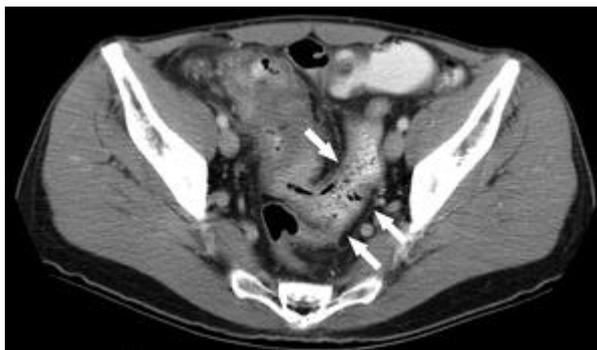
Small-bowel obstruction secondary to adhesions. CT scan obtained shows transition point (arrows) with dilated bowel proximally and collapsed bowel distally. No pathologic process is visualized at transition point, and transition is smooth. This obstruction was found to be adhesional in nature.
